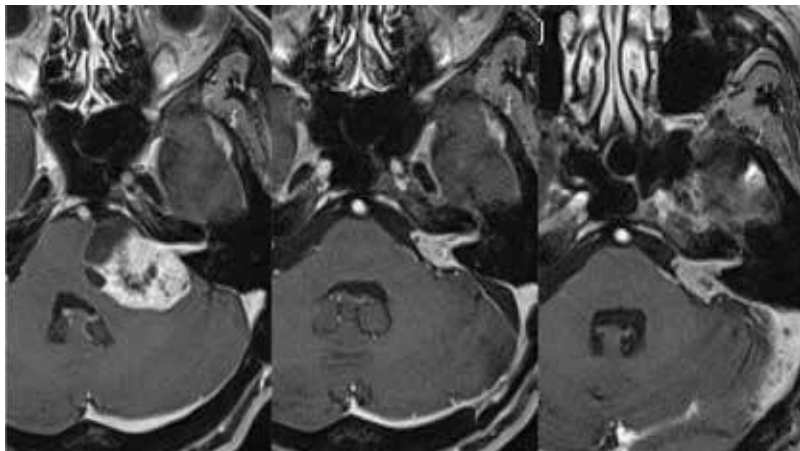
Axial MRI (T1-with contrast) of a case of partially cystic VS (T4a), subtotal removal-retrosigmoid approach. Follow-up MRI after 18 months (image in the middle) showed residual tumor, after 31 months (image on the right) showed progress in size of the residual tumor, so that radiosurgery was indicated.
